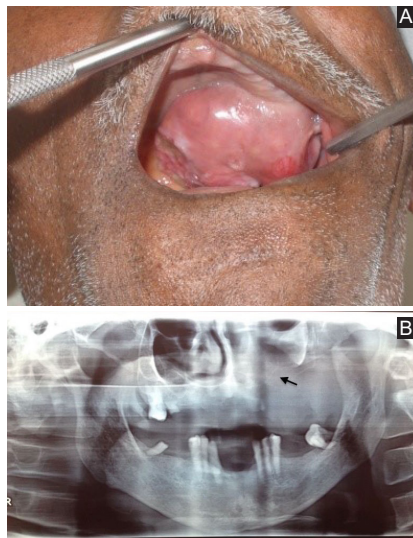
A) Image of palatal swelling crossing the midline and postero-medially showing erythematous to ulcerated areas. B) Orthopantomograph showing radiolucency in the left maxilla and maxillary sinus area, along with the displacement of nasal septum [Indicated by an arrow].
